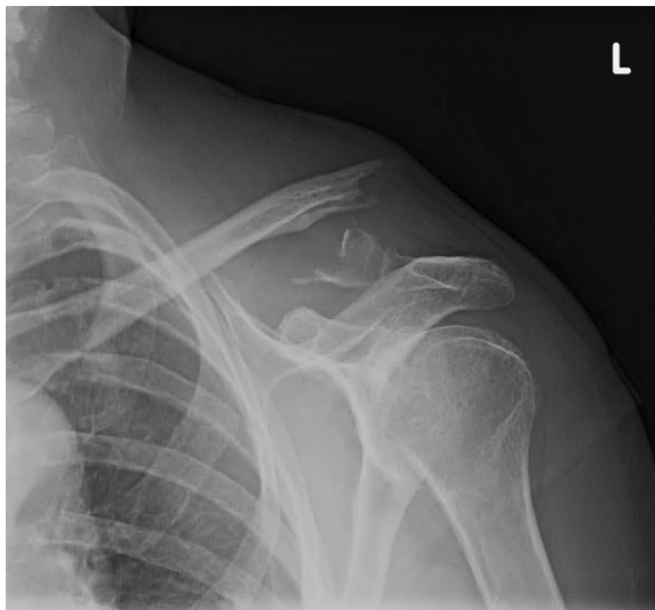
Preoperative anteroposterior radiograph of a comminuted, displaced Neer type 2 distal clavicle fracture.
